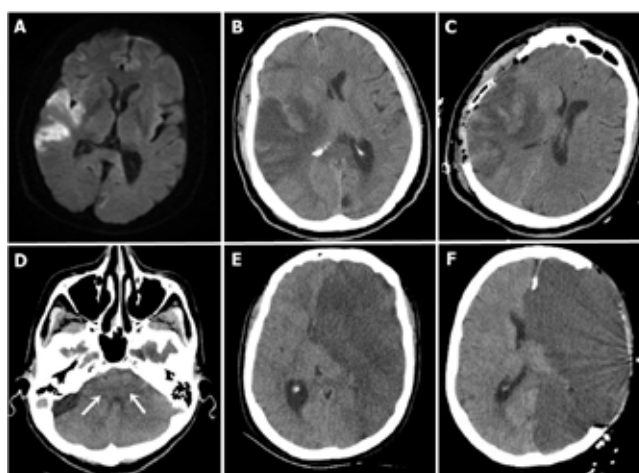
Patient 1; A) Preoperative diffusion weighted imaging (DWI) showed right MCA infarct, B) Preoperative CT showed midline shift, C) Postoperative Ct after decompression, Patient 2; D) Preoperative CT showed closed basal cisterns (white arrows), E) Preoperative CT showed left ICA infarct with midline shift, F) Postoperative CT after decompression
